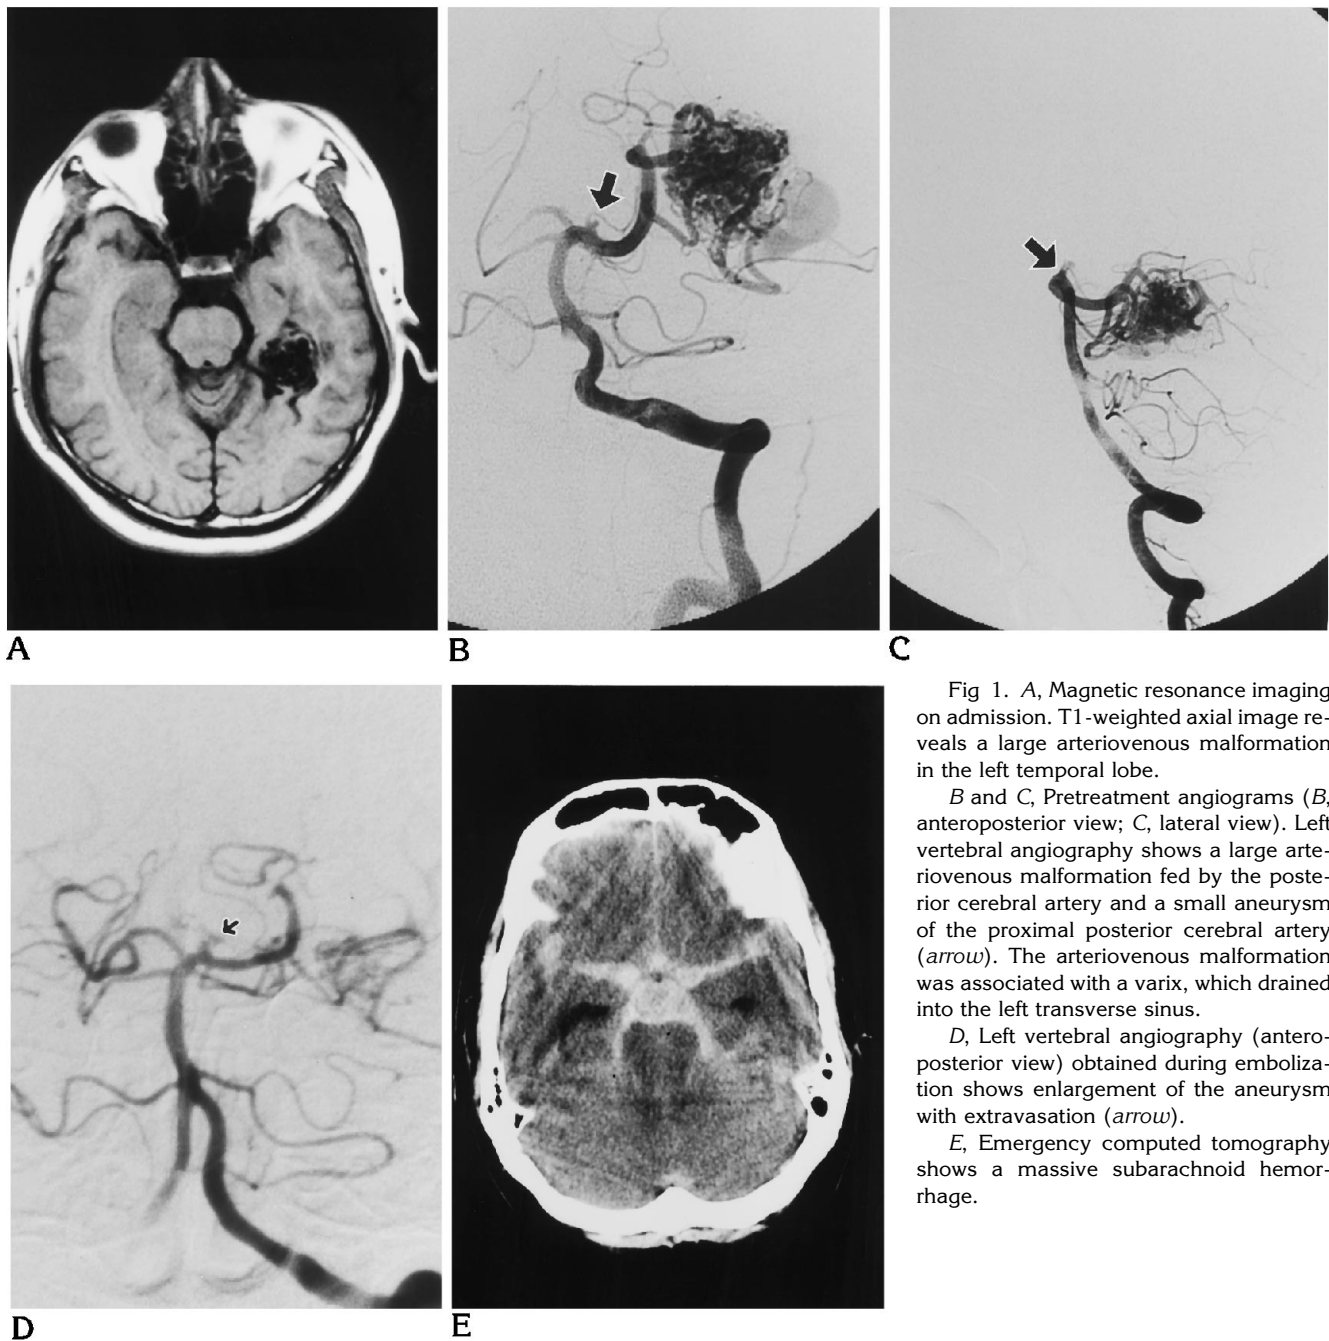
A, Magnetic resonance imaging on admission. T1-weighted axial image reveals a large arteriovenous malformation in the left temporal lobe.
